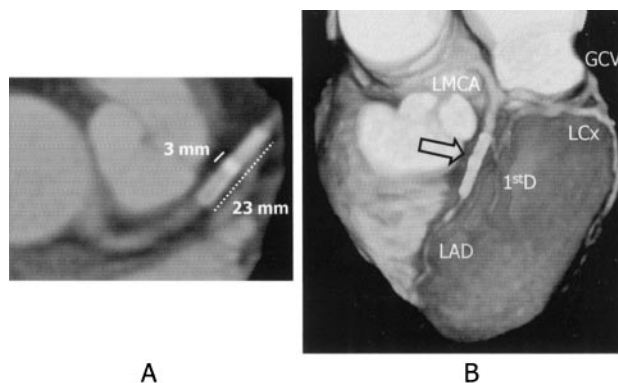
MSCT images. A, CT axial scan through the aortic root showed 2 stents in the mid left anterior descending (LAD); total length was 23 mm (dotted line) with a 3-mm overlapping segment (solid line). B, 3-D rendering of the heart and coronary arteries with manual segmentation of cross-sectional images. Left coronary system can be identified. LMCA indicates left main coronary artery; LCx, left circumflex; 1stD, 1st diagonal branch; and GCV, great cardiac vein. The stented segment (arrow) is localized in the mid LAD.
